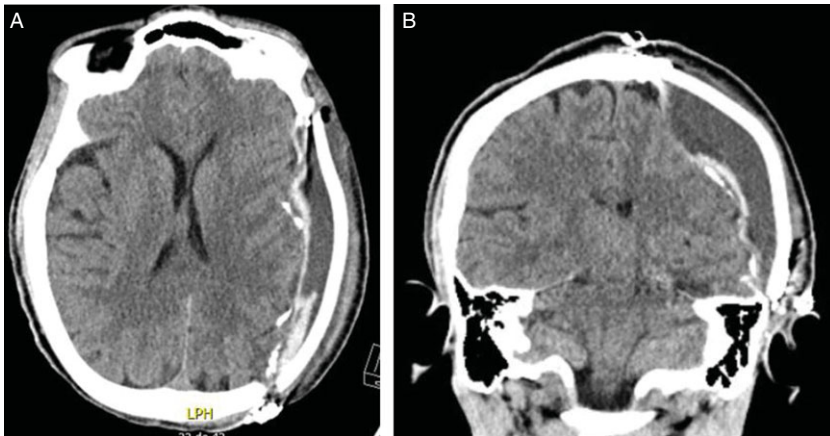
(A) Axial and (B) coronal non-contrast head CT of a 39-year-old patient with cranioplasty complicated by epidural hematoma showing midline shift and mass effect.
